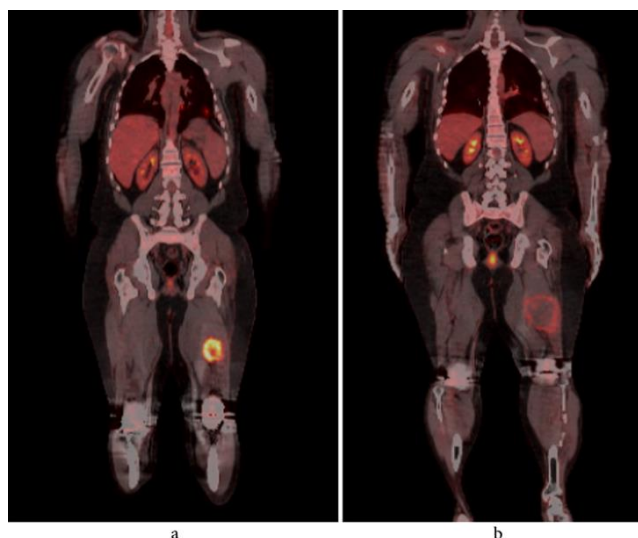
Regorafenib images-1: (a) Baseline imaging before regorafenib—Focal pathological activity in the middle lower part of the left femur (SUVmax: 13.4) and nodular lesion in the left lung and left hilus (SUVmax:8.1) & (b) Four months after starting regorafenib—The size of the existing lesion in the femur increased but the pathological activity decreased (SUVmax: 5.7) and the metabolic activity of nodules in the left lung and hilus has decreased (SUVmax: 4.5) (reprinted with permission of patient)
